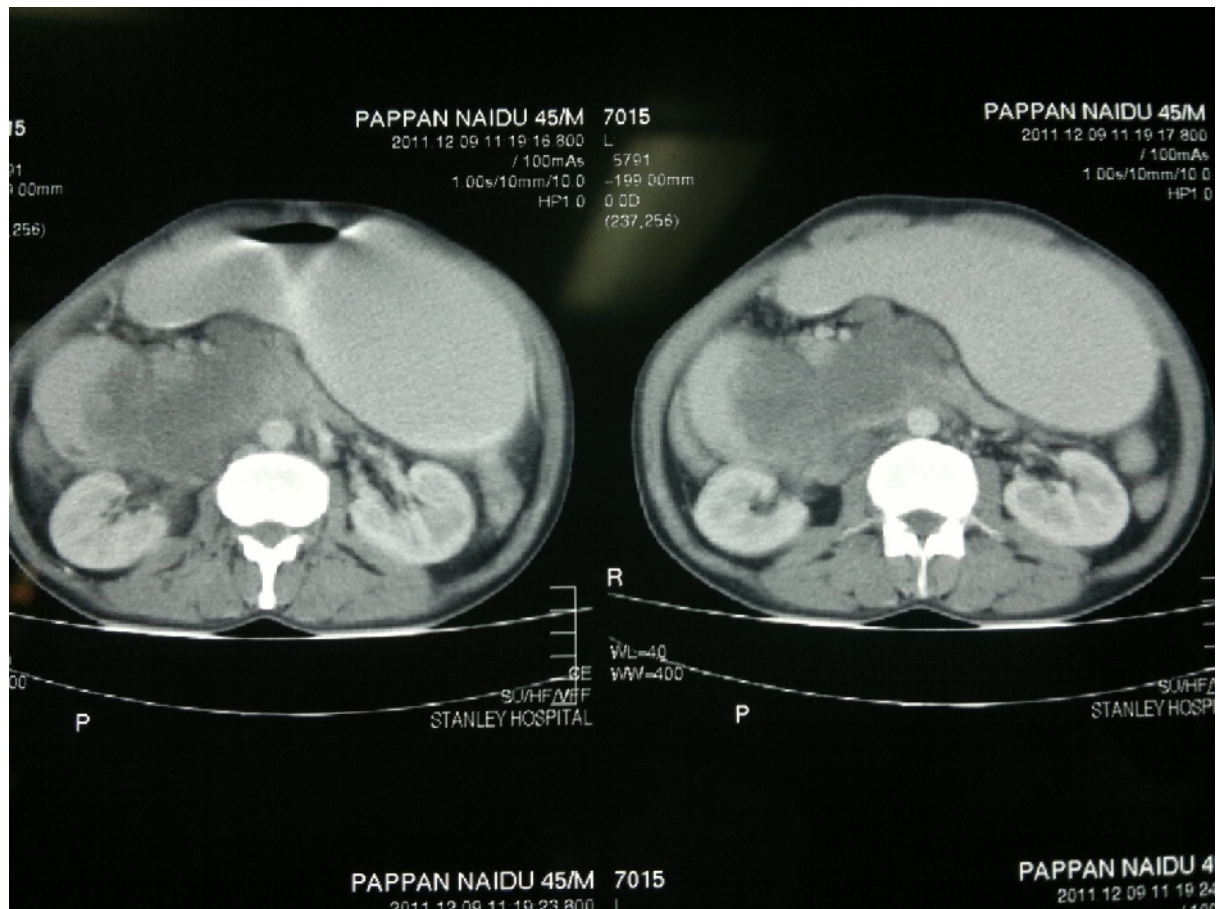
This CT scan shows a mass lesion in the head of pancreas,local infiltration into first and second portions of duodenum,and encasement of superior mesenteric pedicles.The disease was deemed inoperable pre operatively based on CT.His CA 19-9 levels was 18 U/L.Only a palliative bypass procedure was done.
